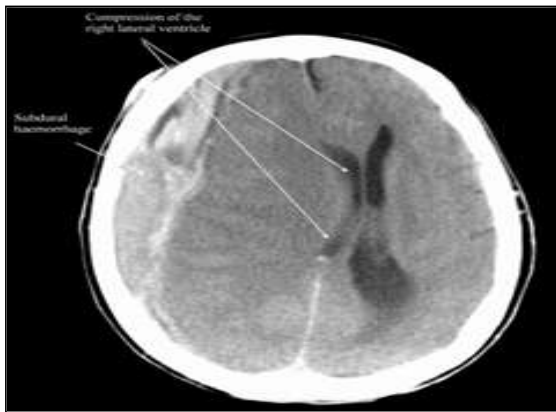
Axial CT scan demonstrating a crescent-shaped hyperdense extra-axial collection along the cerebral convexity (arrow), suggestive of subdural hematoma with midline shift towards left and compression of ipsilateral lateral ventricle.
